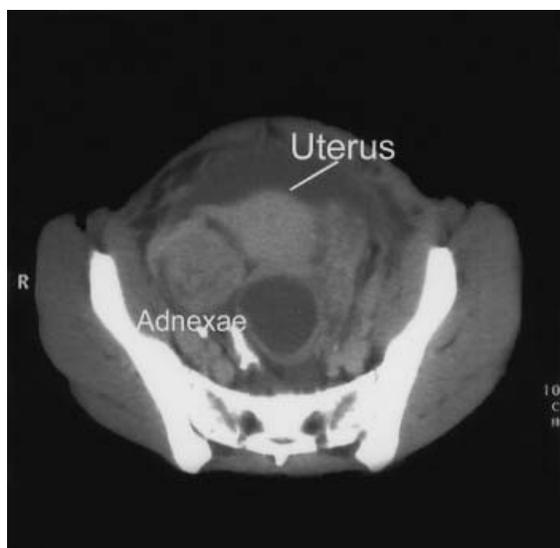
Representative CT scan.
